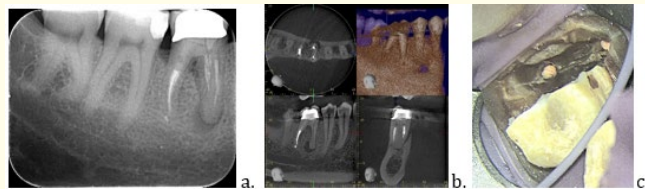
a. preoperative radiograph b. preoperative CBCT c. intraoperative image showing vertical mesial root fracture.
